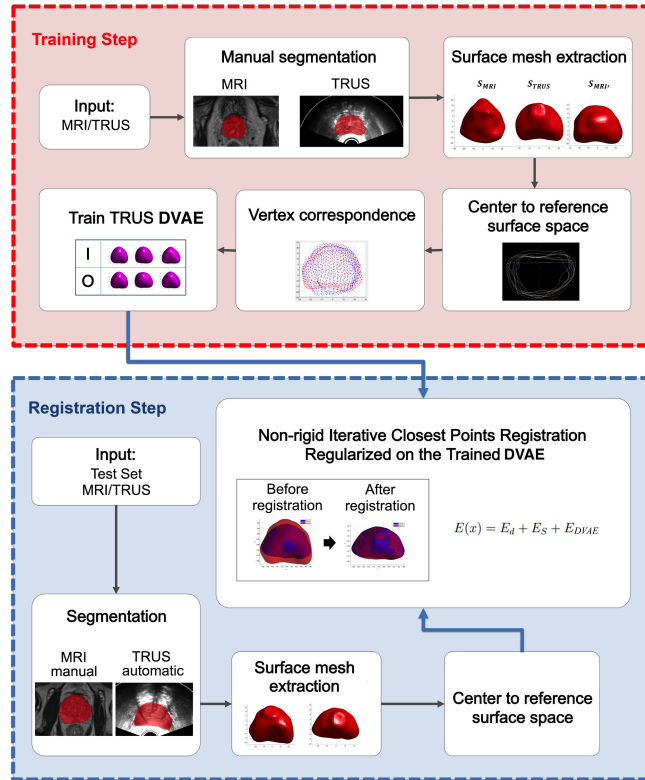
Top Offline training phase of the deep variational auto-encoder using MRI-aligned TRUS prostate surface meshes, with S'_{MRI} as the deformed mesh. Bottom Online registration phase, performing segmentation using FC-ResNet trained on the 2D TRUS slices. At prediction time, the FC-ResNet predicted prostate meshes which are used to obtain the latent space embedding for used in the NICP algorithm, generating a deformed prostate surface.
